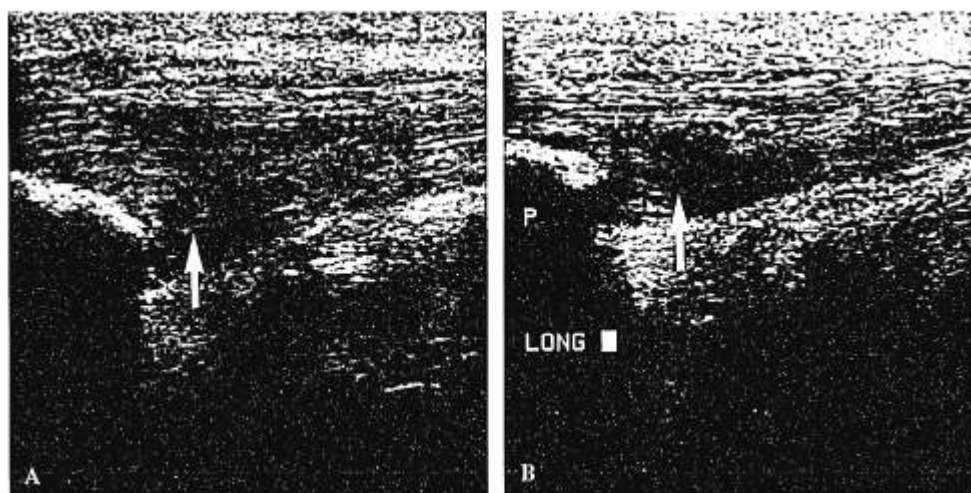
Patellar tendon ultrasound appearances in two patients with vastly different clinical outcomes 12 months after surgery. (A) Longitudinal ultrasound image of a 39-year-old patient with an excellent clinical outcome. (B) Ultrasound image obtained in a 27-year-old patient with a poor clinical outcome. Despite the difference in clinical outcomes, both scans reveal large hypoechoic areas in the patellar tendon (arrows).
